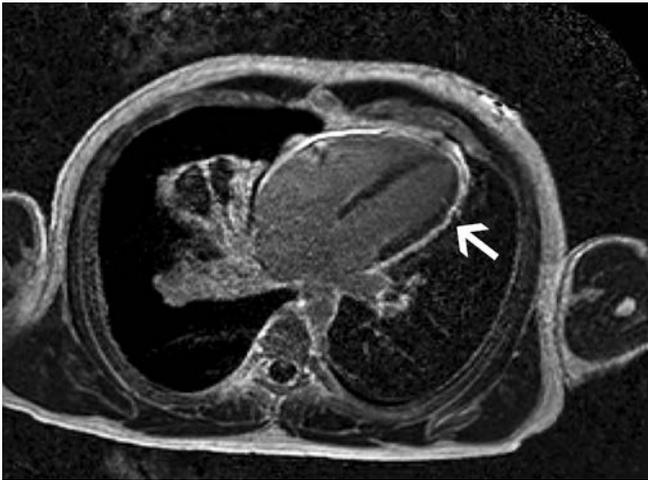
Cardiac MRI PSIR (phase sensitive inversion recovery) post gadolinium contrast imaging demonstrating a small pericardial effusion, pericardial thickening with evidence of enhancement (arrow).
